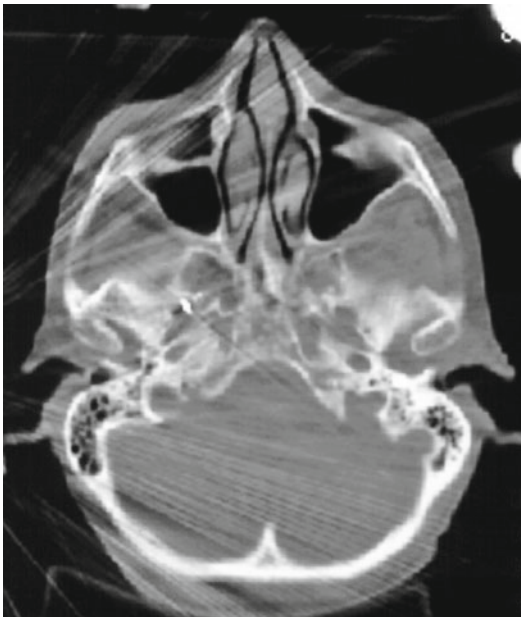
Axial control CT showing the needle in the right foramen ovale
